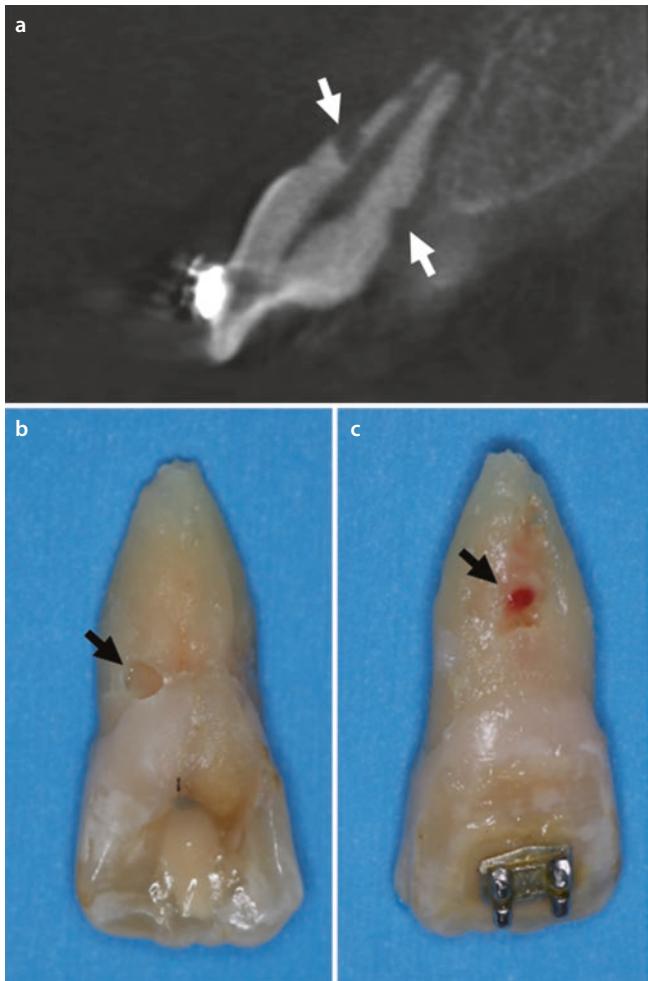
CBCT coronal a orthogonal plane shows EIR on the lingual and buccal (white arrows) aspect of tooth #9 with history of second avulsion >90 min. Resorption defects could be visually seen (black arrows) on lingual b and buccal c aspects of avulsed tooth. (Courtesy of Tyler Schuurmans, DDS, MS)
